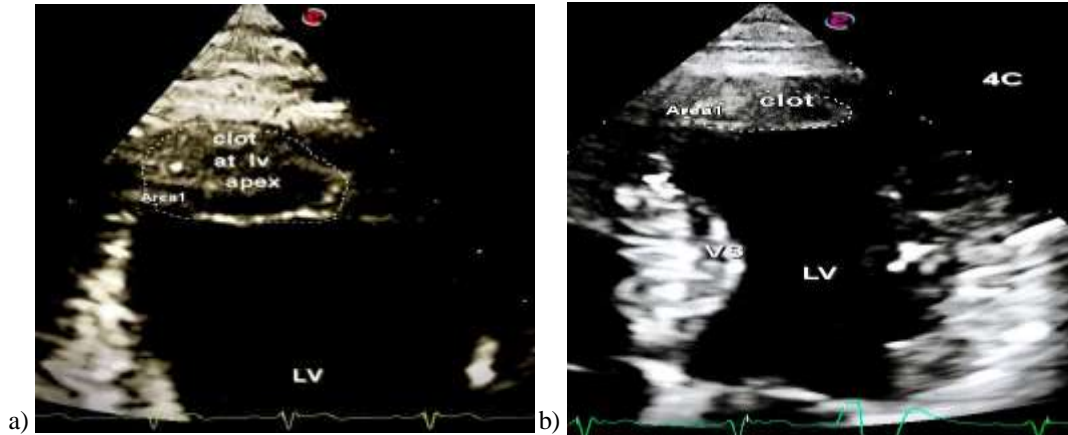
Transthoracic Echocardiography in 4CH View, (a), on the left panel in diastole and (b), on the right panel in systole, reveals a hazy and unclear image of LV apical thrombus, highlighted by tracing the edges of the thrombus with dotted line.
